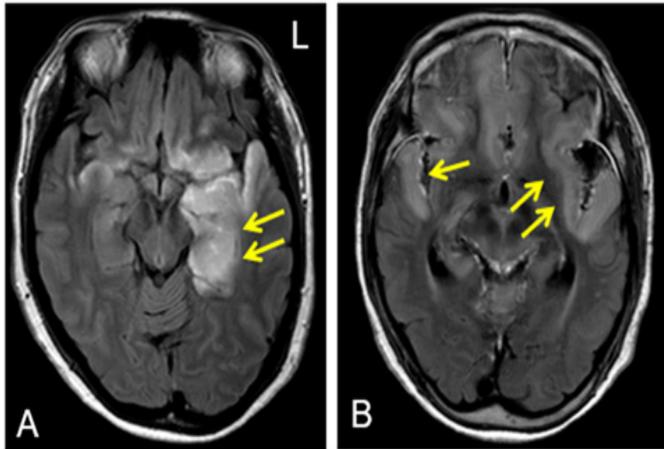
MRI findings of a patient with herpes simplex virus-1 encephalitis (HSE) and a patient with herpes zoster encephalitis (HZE).
